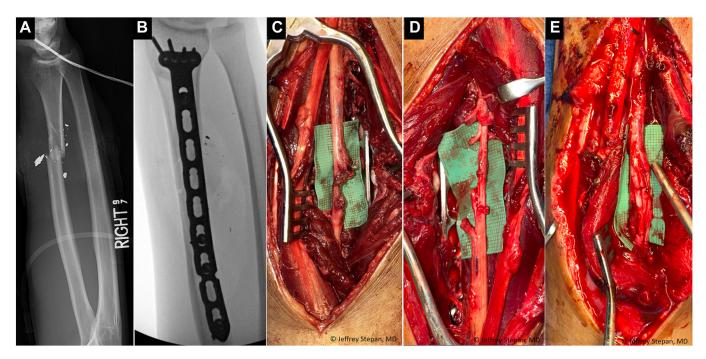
GSW injury sustained with median nerve deficit and radial shaft fracture. A Initial Spot film radiographs of the right forearm. B Intraoperative fluoro demonstrating fixation of the radial shaft fracture. C Exploration of the median nerve at time of fracture fixation 8 days after injury demonstrating a partial nerve laceration. D Intraneural dissection and identification of healthy fascicles and injured fascicles. E Nerve grafting of the median nerve.
